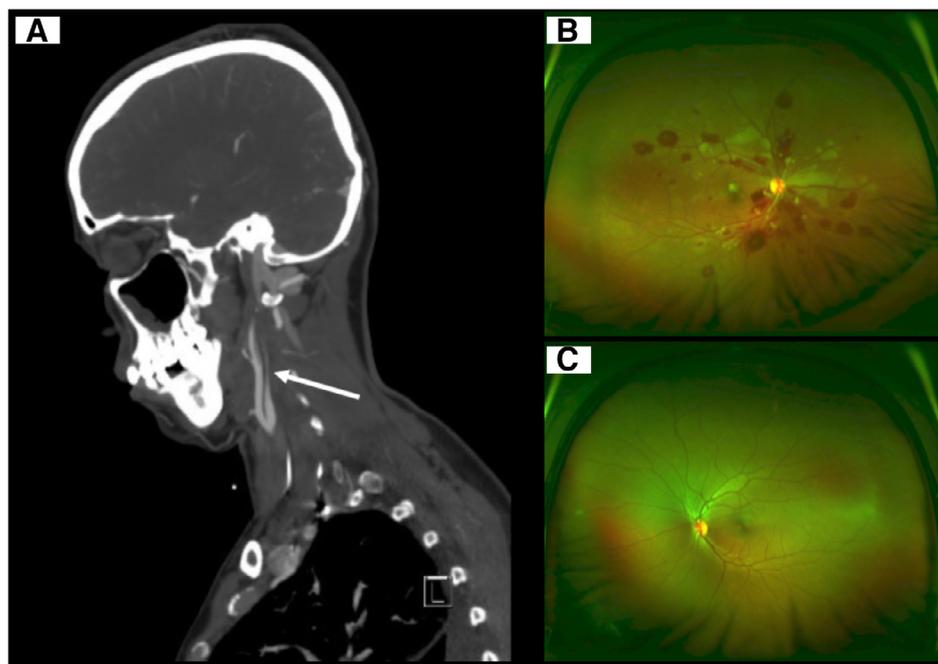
(A) Computed tomography angiogram (CTA) reveals a right internal carotid artery (ICA) that is narrowed secondary to a right ICA dissection (arrow). The left ICA appears normal. (B) Fundus photograph OD showing characteristic polygonal areas of Purtscher flecken along with cotton-wool spots, Roth spots, and retinal hemorrhages. (C) Fundus photograph OS showing a normal retina.
